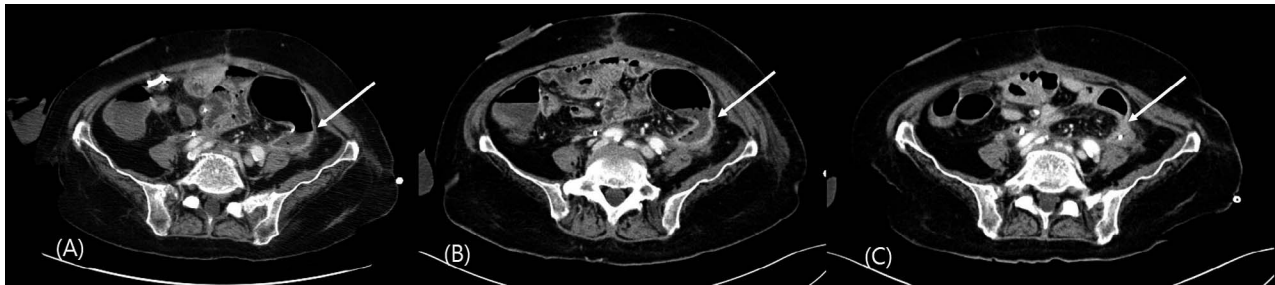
Serial computed tomography scans acquired at (A) 1, (B) 2, and (C) 3 weeks after catheter placement. Note the gradual decrease in size of the abscess, with obliteration of the sinus.
